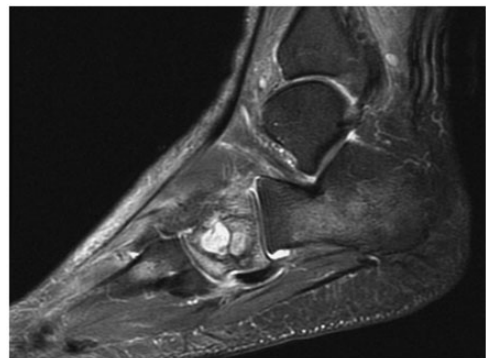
Sagittal view of a T2-weighted (T2W) magnetic resonance imaging (MRI) scan of the injured foot which showed multilocular fluid collection over right cuboid bone.
